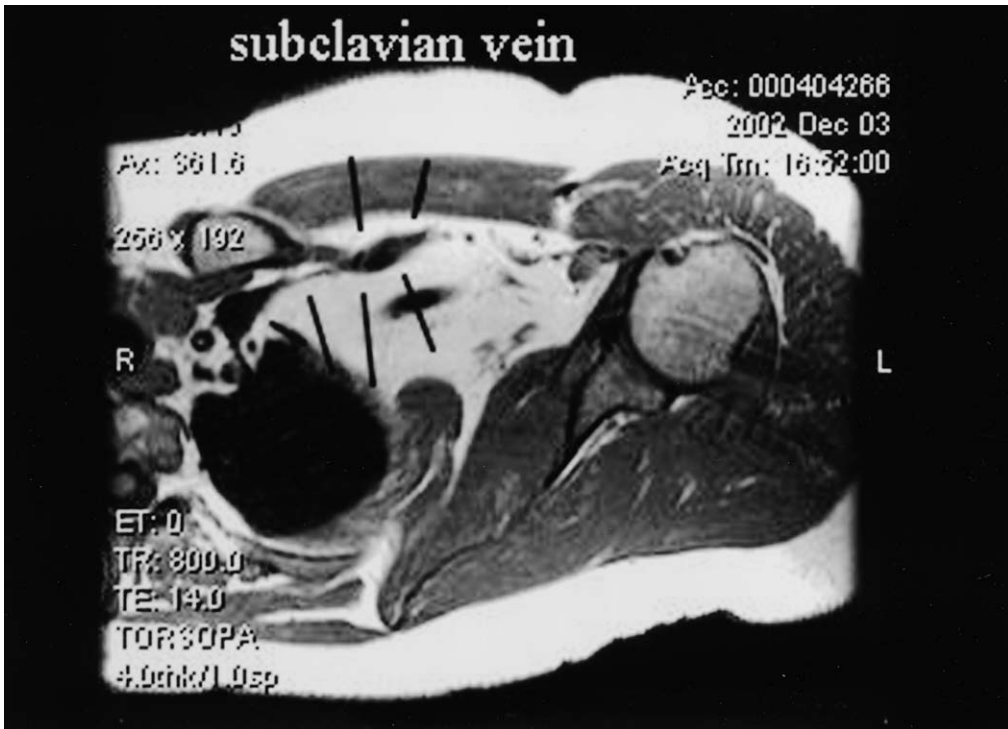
Magnetic resonance image of the subclavian vein in the same patient shown in Fig. 1. Note anterior–posterior compression of subclavian vein not appreciated on conventional venography.
